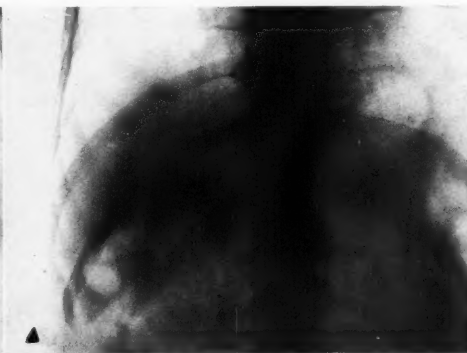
The same case: radiograph of the abdomen before injection.
